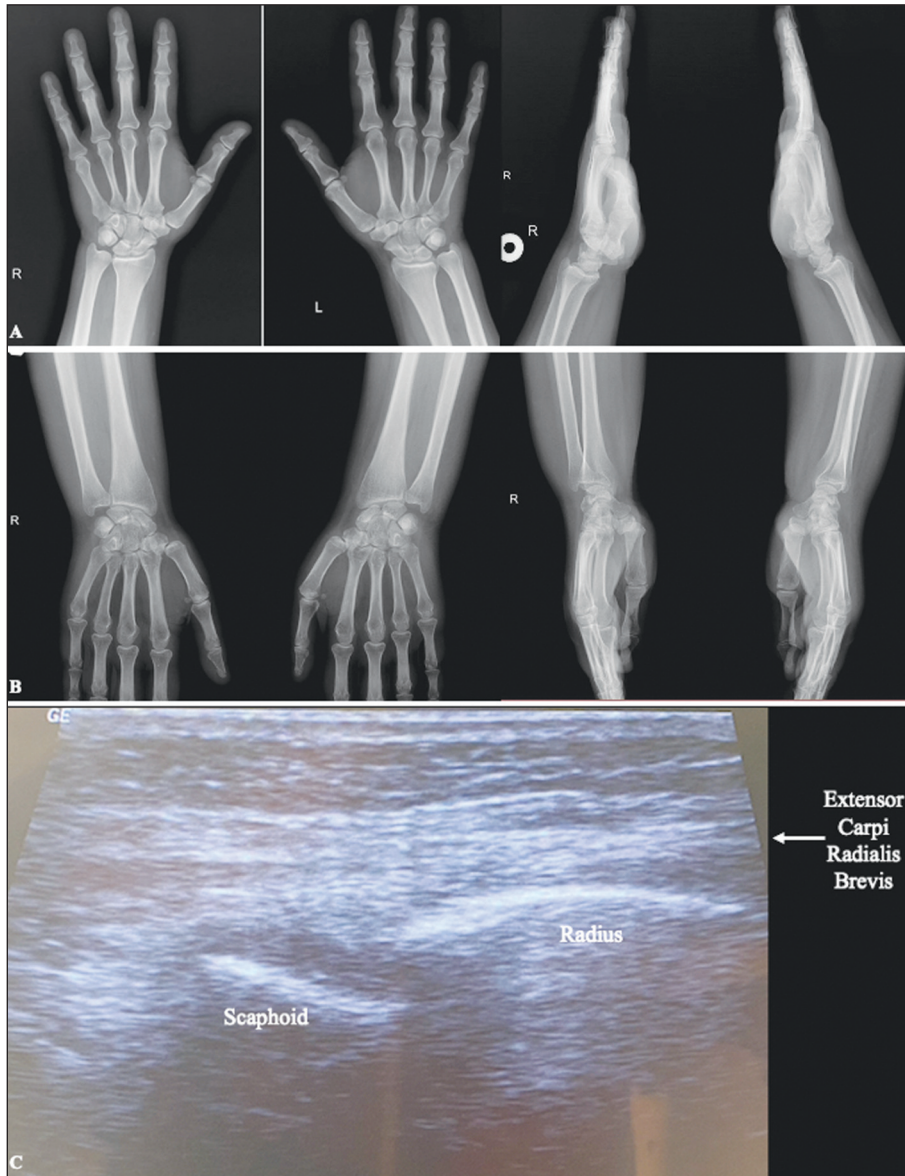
Wrist X-rays of Case 1 (A) and Case 2 (B). Ultrasound image of Case 2 (C) showing radiocarpal effusion. Note the anechoic (black) fluid just in front of the scaphoid.
